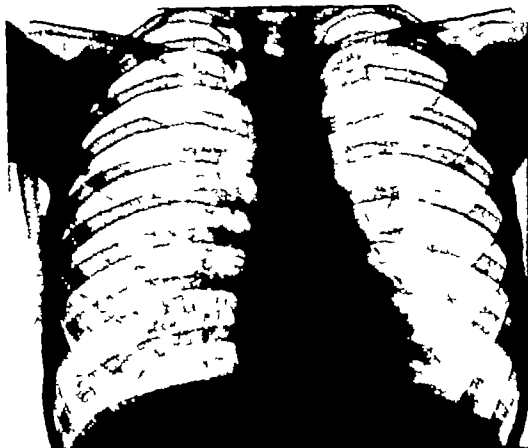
13 (a).—Radiograph showing translucency of left lung field in a child with cough and sputum. Because of the emphysema of the upper lobe a bronchogram was done (Fig. 8 13 (b)).
